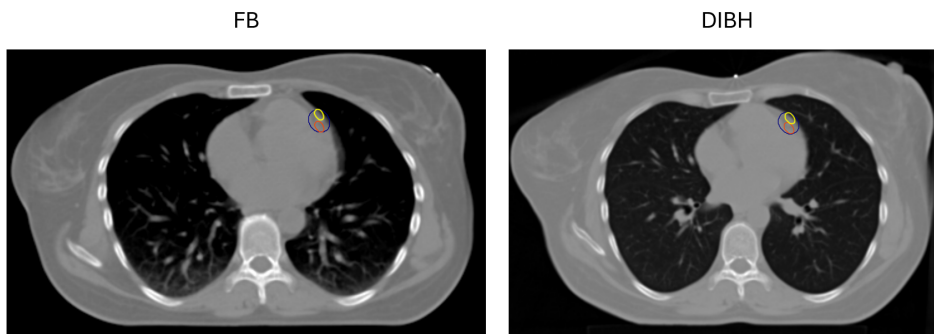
CT images display PRV contours associated with the LAD in dark blue, alongside contours displaced towards the anterior (yellow) and posterior (orange).
